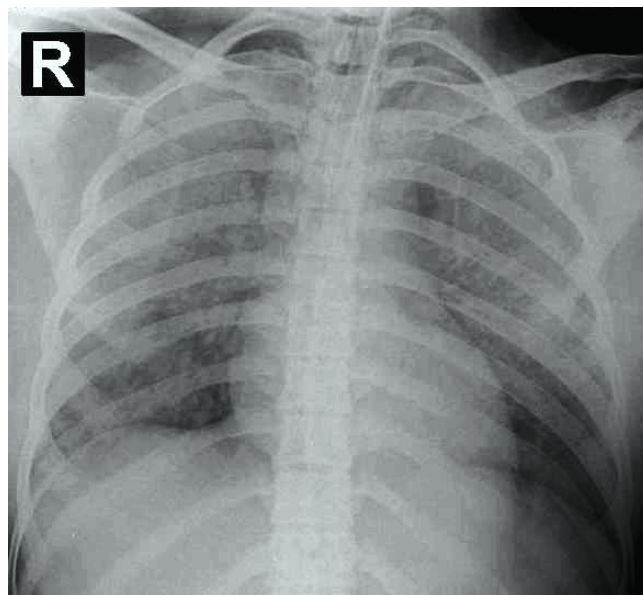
Chest radiograph on admission showing bilateral diffuse airspace infiltrates.
